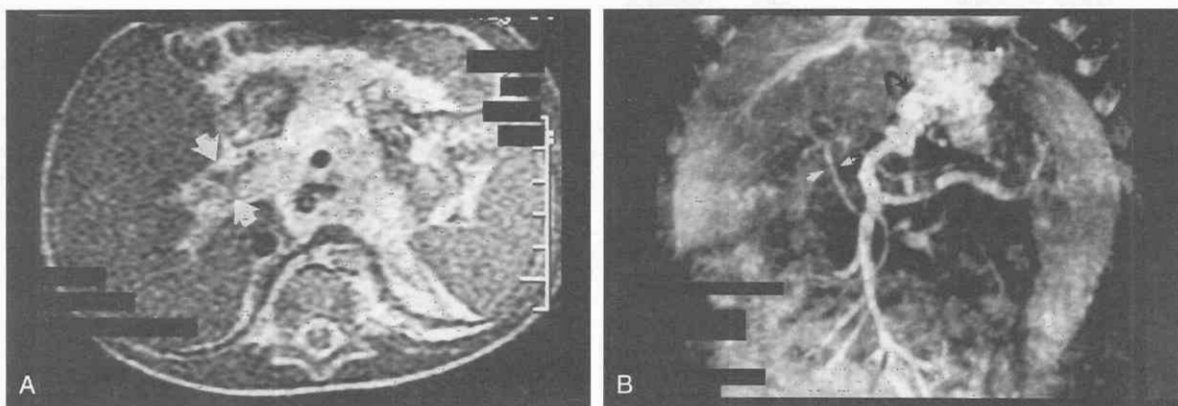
Cavernous transformation of the portal vein. A, Axial MR image reveals numerous small collateral veins in the portal hilum (*arrows*) with no normal portal vein visible. B, MRI venogram shows absence of the main portal vein. The hepatic artery (*arrows*) alone is visible entering the liver hilum. Large gastric varices (*curved arrows*) are present.
